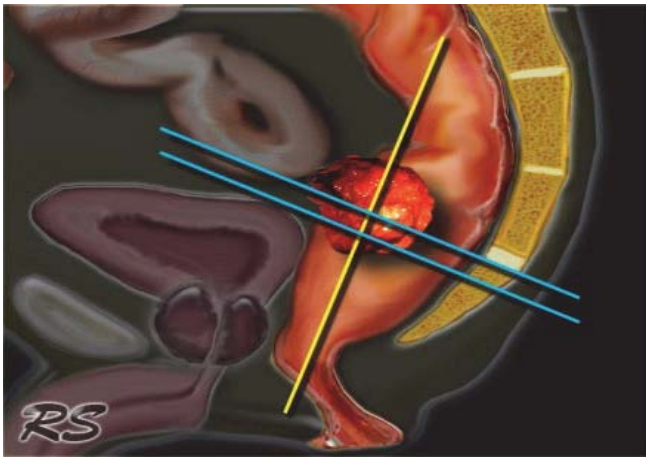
Scanning of rectal cancer with MRI
